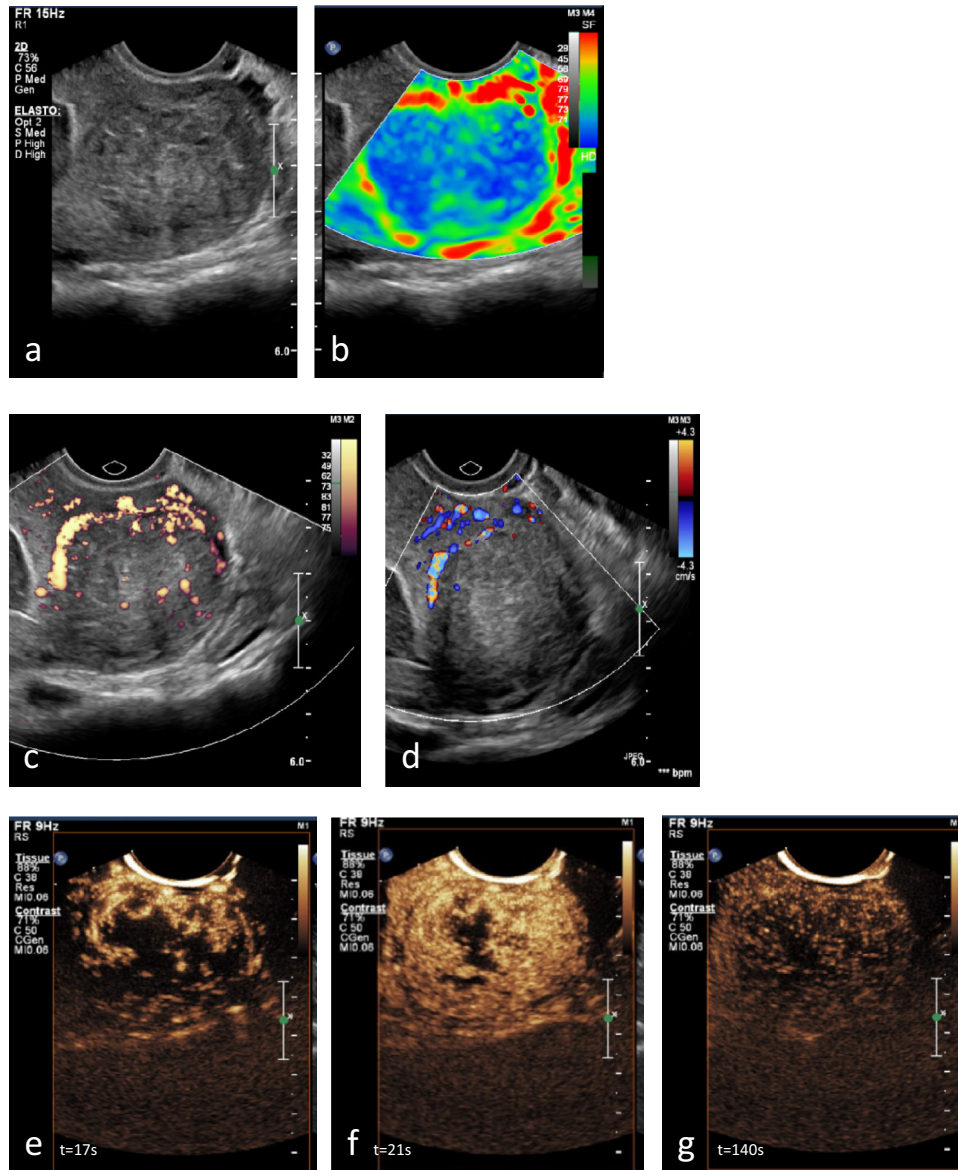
Subserosal fibroid (4.2 cm). All images were obtained from the second patient. (a) Gray-scale ultrasound image revealing a well-delineated fibroid. (b) Sonoelastography image revealing the fibroid's center in *blue* (stiff tissue) with a pseudo-capsule in *red* (soft tissue). Small *green* areas indicating softer tissue are present in the fibroid's center. (c) Power Doppler image revealing a circular vascular network proximal to the fibroid, that is, the pseudo-capsule, and a few larger vessels in the fibroid's center. (d) Color Doppler imaging revealing the proximal part of the pseudo-capsule. (e) Contrast-enhanced ultrasound image obtained 17 s after contrast injection ($t = 17$ s), revealing peripheral enhancement with vessels from the exterior to interior of the fibroid during wash-in of contrast. (f) Contrast-enhanced ultrasound image at $t = 21$ s revealing heterogeneous enhancement of the entire fibroid with hypo-echogenic, avascular areas in the fibroid's center. (g) Contrast-enhanced ultrasound image at $t = 140$ s revealing gradual wash-out of contrast from the fibroid.
